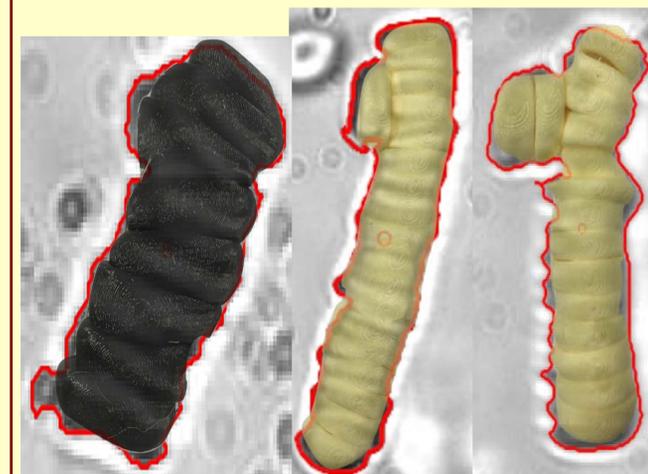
3D print overlaid into X-Ray 1
